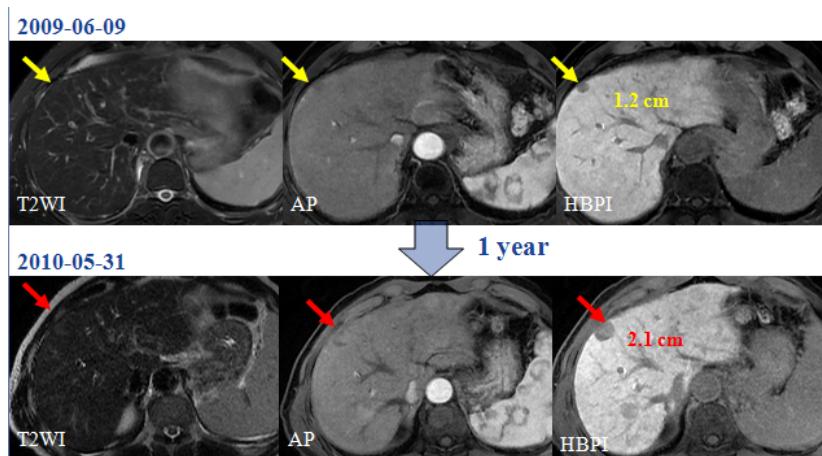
Gadoxetic acid-enhanced MR images of a hepatocellular nodule in a 61-year-old man with hepatitis B-related Child-Pugh class A liver cirrhosis. A-C: Initial MRI with administration of gadoxetic acid. The nodule (arrow) shows hypointensity on arterial phase image and on hepatobiliary phase image. D-F: Gadoxetic acid-enhanced MR images obtained 11.9 months after initial scan. The lesion (arrow) shows arterial enhancement, increased SI on T2WI and interval growth from 12.0 mm to 20.6 mm. Final pathology diagnosis after resection was grade I HCC.
